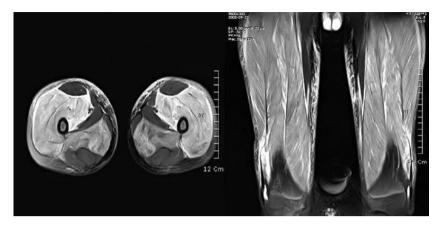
A magnetic resonance imaging(MRI) showed diffuse, increased signal intensity at both quadriceps and adductor magnus muscles and a thickening of fasciae on T2 weighted images.
